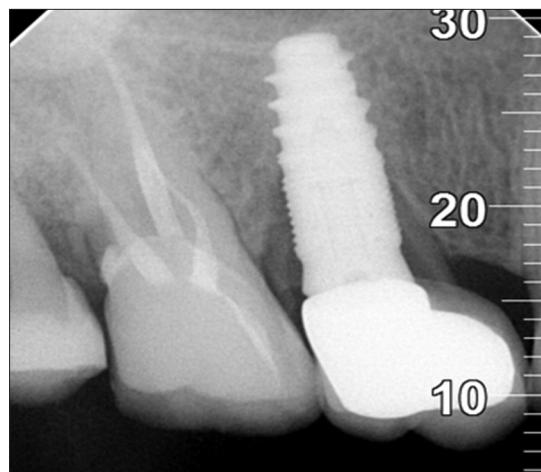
Periapical radiograph with 12-month follow-up
